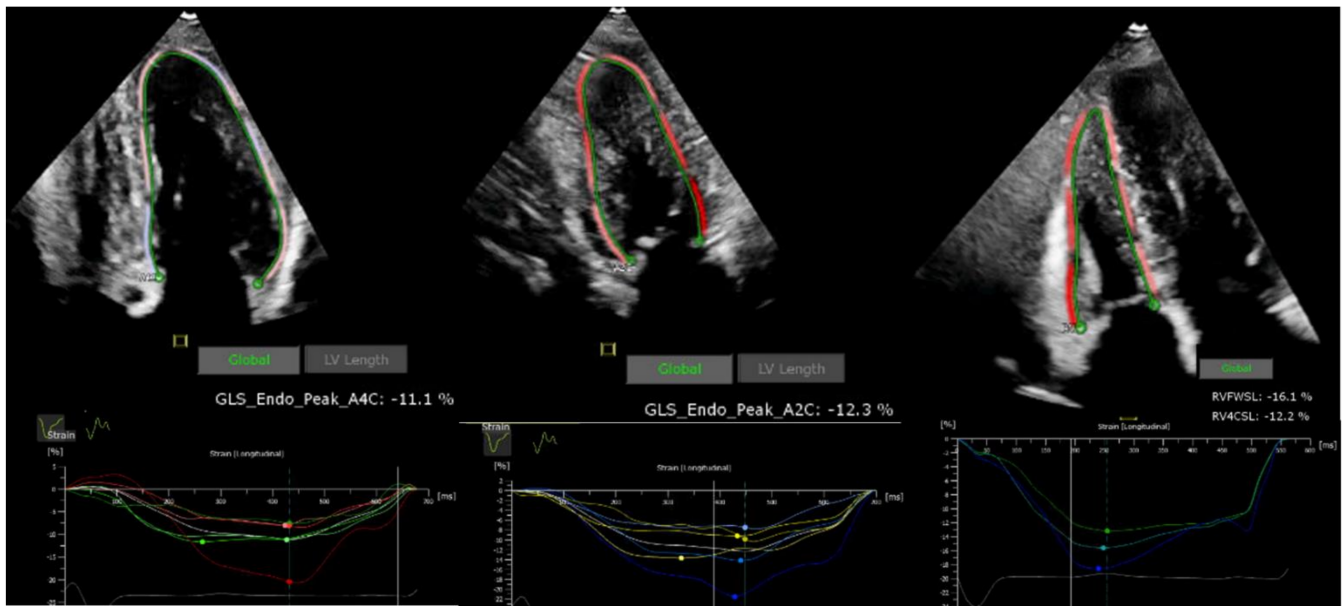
Strain TTE in a patient with Fabry Cardiomyopathy. Left: GLS assessment of the LV from the apical 4-chamber view demonstrating reduced GLS (-11.1%); Middle: GLS assessment of the LV from the apical 2-chamber view demonstrating reduced GLS (-12.3%); Right: GLS assessment of the RV from the Apical 4-chamber view demonstrating reduced GLS (free wall strain -16.1% and longitudinal strain -12.2%).
